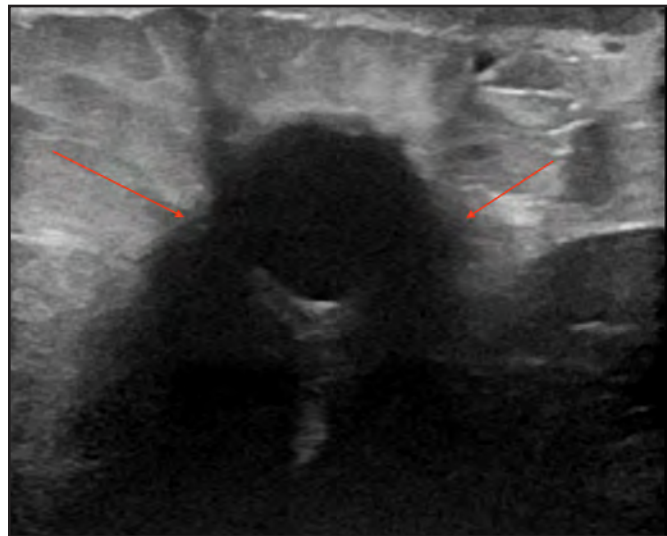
Targeted B-mode ultrasound of the 12 o'clock subareolar region of the right breast in the transverse plane demonstrates a fluid collection with indistinct margins (arrows) corresponding to the mammographic finding.
